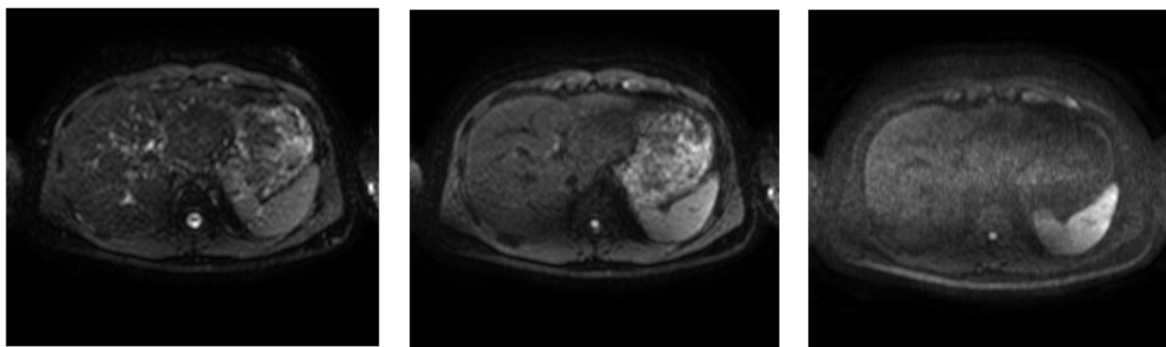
Axial slices of DWI acquisition in a healthy patient for *b-values* of 0, 100 and 1000 s/mm^2 (from left to right).
